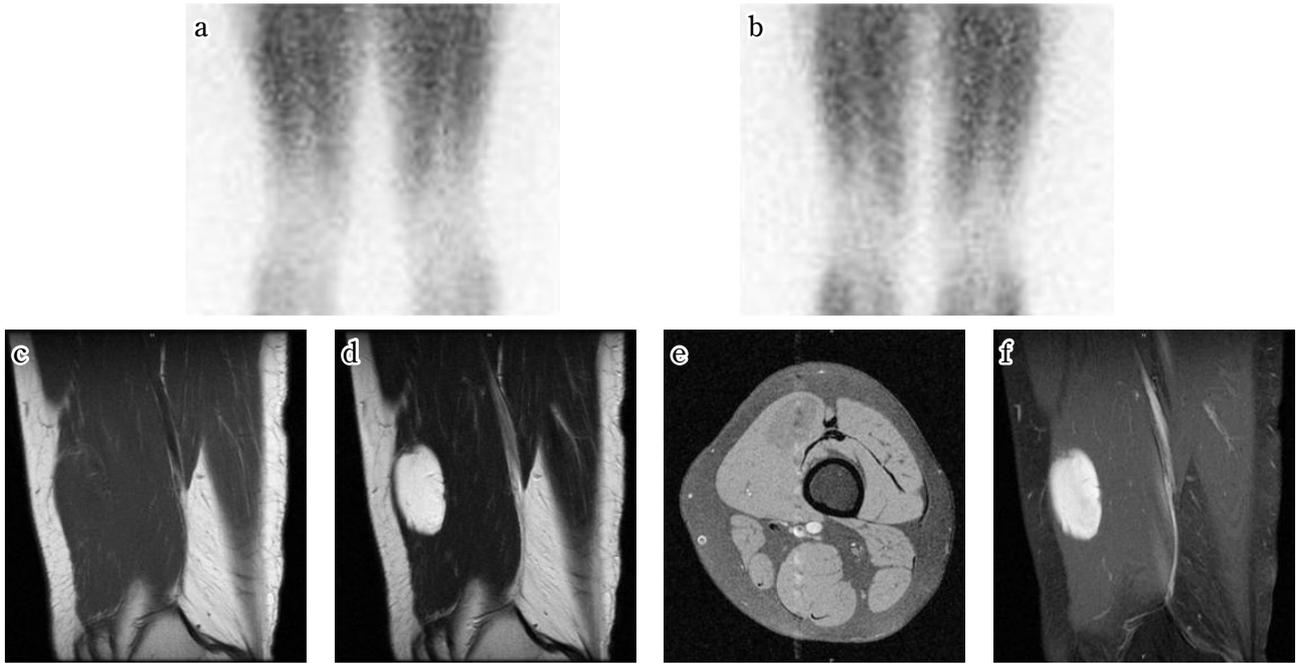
Liposarcoma (myxoid type) in the left femur. Iso uptake pattern in both early and delayed phase in malignant lesion. a : early phase image of $^{201}\text{TlCl}$ scintigraphy. b : delayed phase image. The tumor showed iso uptake in both phases of $^{201}\text{TlCl}$ scintigraphy. c : Sagittal T1-weighted SE MR image. d : Sagittal T2-weighted SE MR image. e : Axial T1 weighted SE MR image with fat suppression. f : Sagittal gadolinium-enhanced T1-weighted SE MR image. The tumor, measuring $30 \times 17 \times 45$ mm, showed iso intensity on T1-WI and high intensity on T2-WI compared to the muscle. The tumor intensity was suppressed on fat-suppressed T1-WI and the tumor showed strong enhancement.
